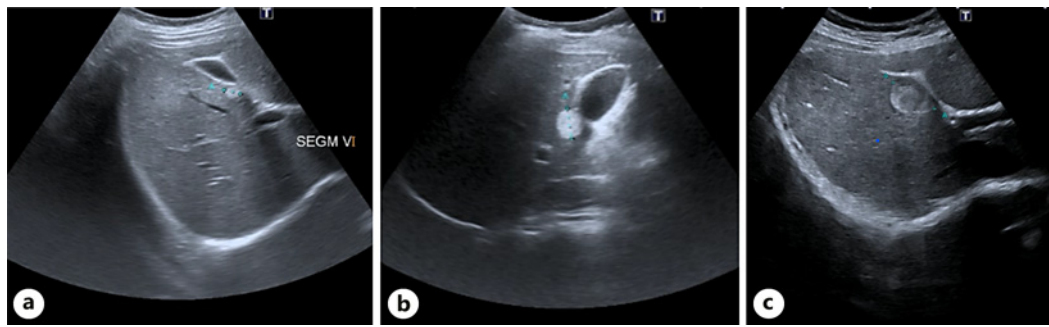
a 2018 ultrasound: hyperechogenic and homogeneous nodule measuring 9 mm in segment 5. b 2019 ultrasound: hyperechogenic and homogeneous nodule measuring 16 mm in segment 5. c 2019 ultrasound: hyperechogenic and homogeneous nodule measuring 16 mm in segment 5.
